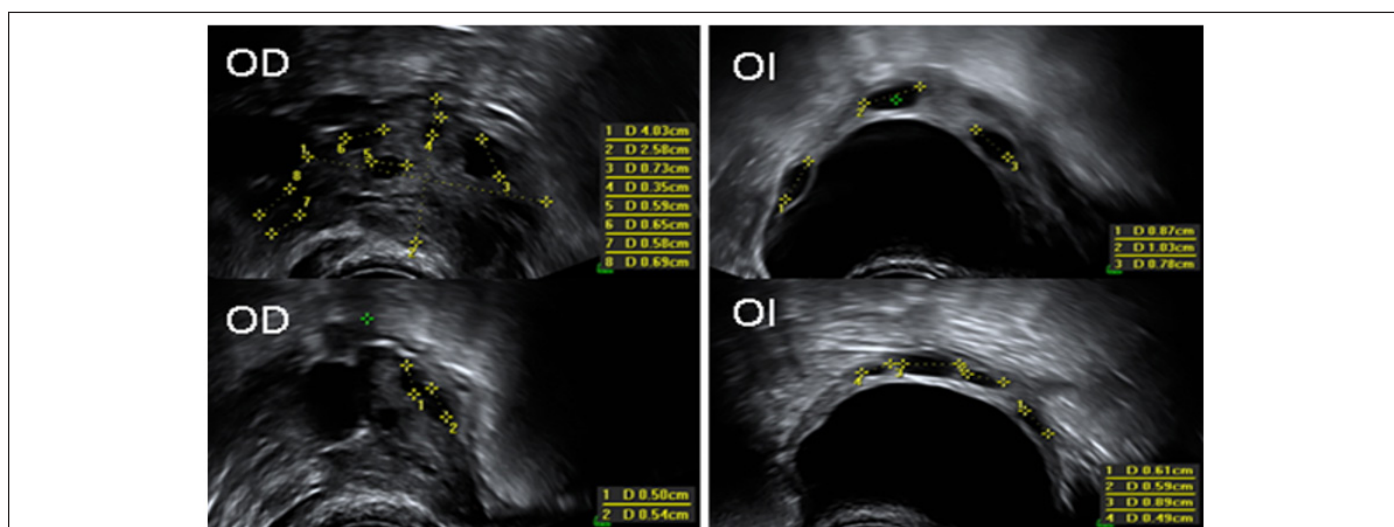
Shows 7 AFC in the right ovary (OD) and 7 AFC in the left ovary (LE), greater than 5mm. Study performed with vaginal ultrasound (Philips, Affiniti 50, with a minimum of 7MHz).
